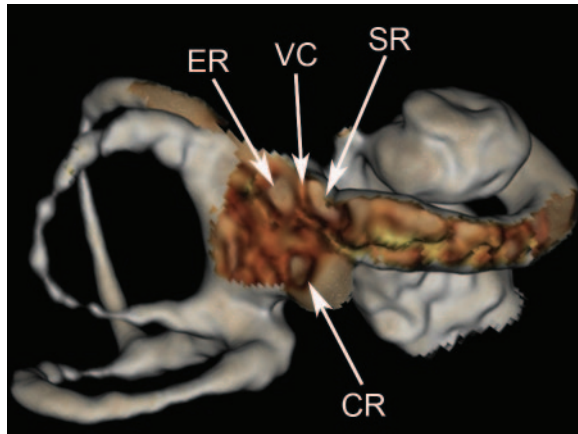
Normal anatomy of the vestibule. Three-dimensional VR CT image (inferolateral view after dissection of the lateral wall of the vestibule) demonstrates the elliptical recess (*ER*) posteriorly and the spherical recess (*SR*) anteriorly, which house the utricle and saccule, respectively. A bony ridge, the vestibular crest (*VC*), lies between the elliptical and spherical recesses. The vestibular crest divides inferiorly into two limbs that form an inverted V and bound a small depression, the cochlear recess (*CR*). The cochlear recess houses the blind opening of the cochlear duct.
